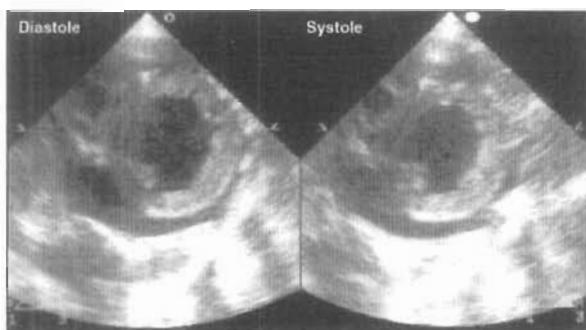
Echocardiogram in the short-axis view showing left ventricular hypertrophy and left ventricular dilation with decreased contraction. A small amount of pericardial effusion is also noted
